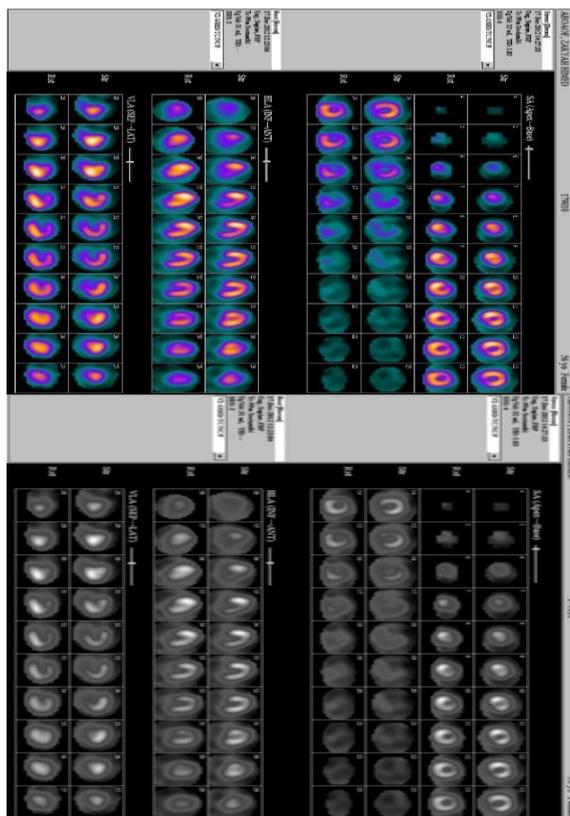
show the SPECT original image of the heart up (colored image) and down show the image after applying the IDL function to transfer it to gray scale image
